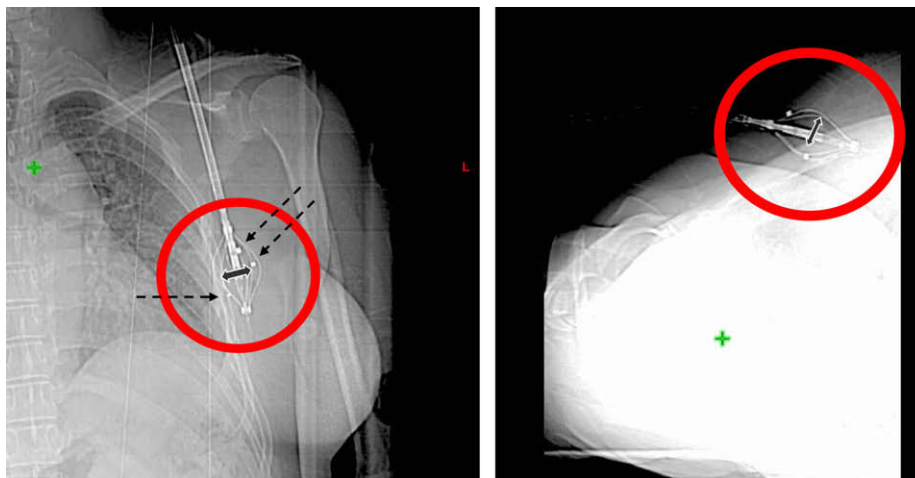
AP and lateral CT scout film that can be checked for rotational motion with reference to the radio-opaque markers on the peripheral struts and anatomical landmarks. The large arrows indicate the distance between the two struts that are furthest apart. This distance is checked prior to each treatment for indication of strut collapse. The dashed arrows point to the radio-opaque markers present on the 2, 4, and 6 peripheral struts.
